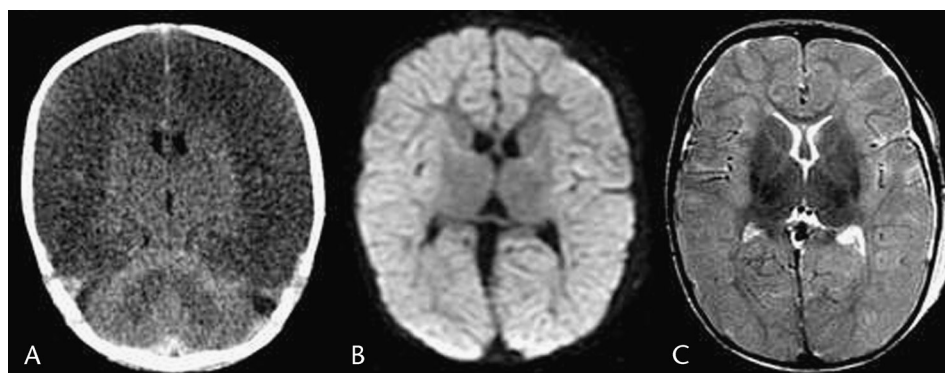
Hypoxic-ischemic injury in a 25-day-old girl. A, Noncontrast CT at presentation shows diffuse cerebral hemispheric hypodensity with loss of gray-white differentiation and less involvement of the basal ganglia, thalami, and cerebellum (white cerebellum sign). Cerebral swelling is associated with effacement of the sulci and ventricles. Magnetic resonance imaging was done the next day. B, Axial DWI shows diffuse high-intensity, restricted diffusion throughout the cerebral cortex (confirmed by apparent diffusion coefficient map). C, Axial T2 image shows diffusely increased intensity of the cerebral cortex with effacement of fissures and sulci.
